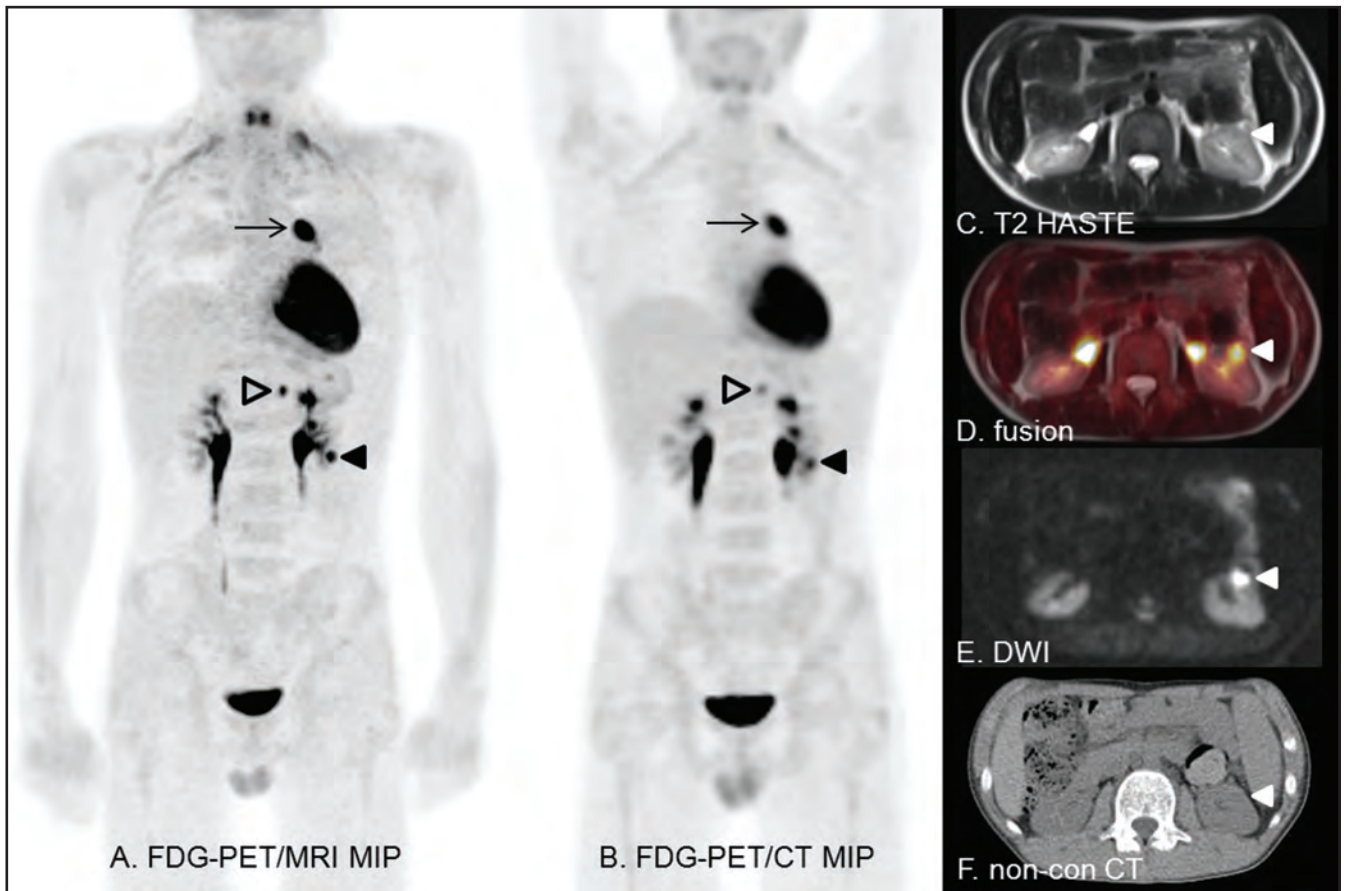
B-cell lymphoma undergoing restaging after chemotherapy. Anterior PET/MRI (A) and PET/CT (B) maximal intensity projection (MIP) images show a hypermetabolic focus in the mediastinum (arrow), which was pathologically proven recurrent disease. A hypermetabolic lymph node (open arrow) is also suspicious for disease involvement. A third lesion in the left kidney (solid arrowhead) is difficult to differentiate from collecting system activity on the CT (F); however, axial HASTE (C), fused (D), and diffusion-weighted (E) MR images show that this represents a renal lesion.
